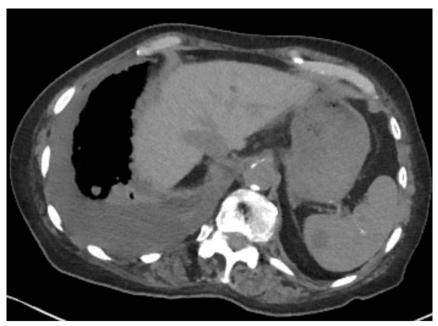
June 2023 CT chest. Axial view. Nodularity of the right pleura with small right pleural effusion, presumably malignant. Thoracentesis performed.
